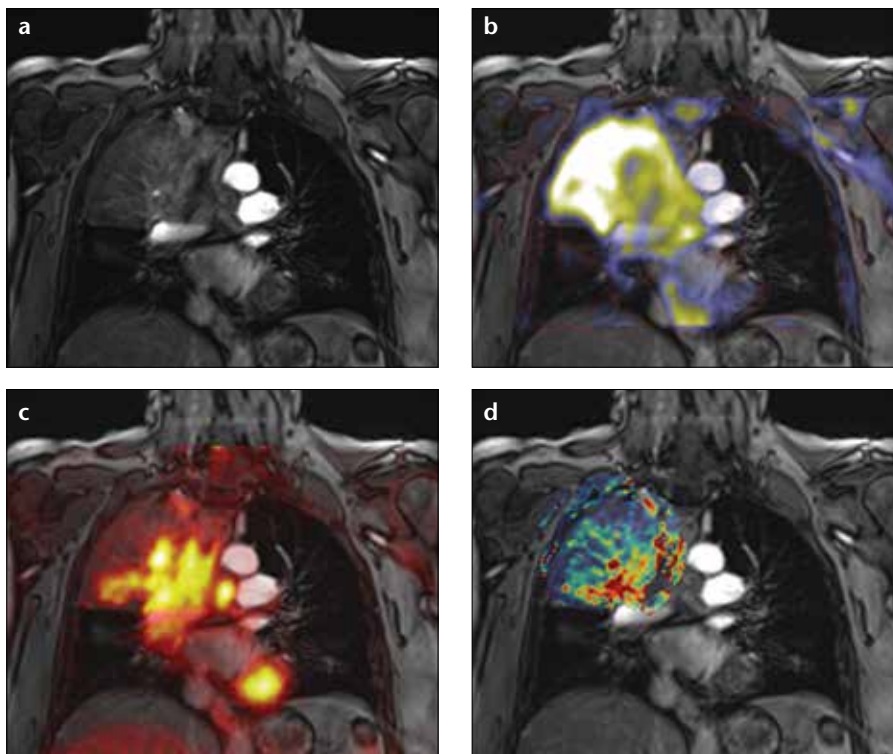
a–d. Multiparametric simultaneous PET/MRI in a patient with non-small cell lung cancer of the right upper lobe. The contrast-enhanced T1-weighted coronal image (a) is fused with the apparent diffusion coefficient (b), FDG-PET (c) and dynamic contrast-enhanced derived transfer coefficient (d). Multiparametric PET/MRI allows for a more holistic understanding of tumor and tumor stroma, potentially enabling better cancer characterization and therapy control.
